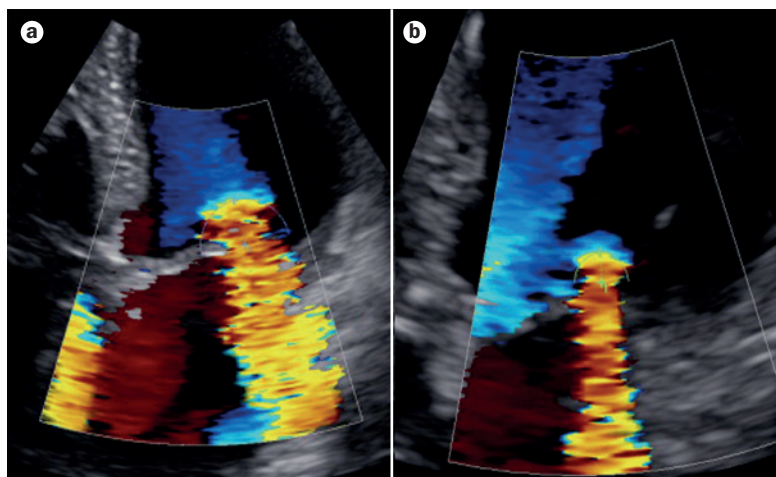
Transthoracic Doppler echocardiogram showing a substantial decrease in secondary mitral regurgitation severity observed after dobutamine administration. a | Effective regurgitant orifice area = 33 mm². b | Effective regurgitant orifice area = 18 mm².
